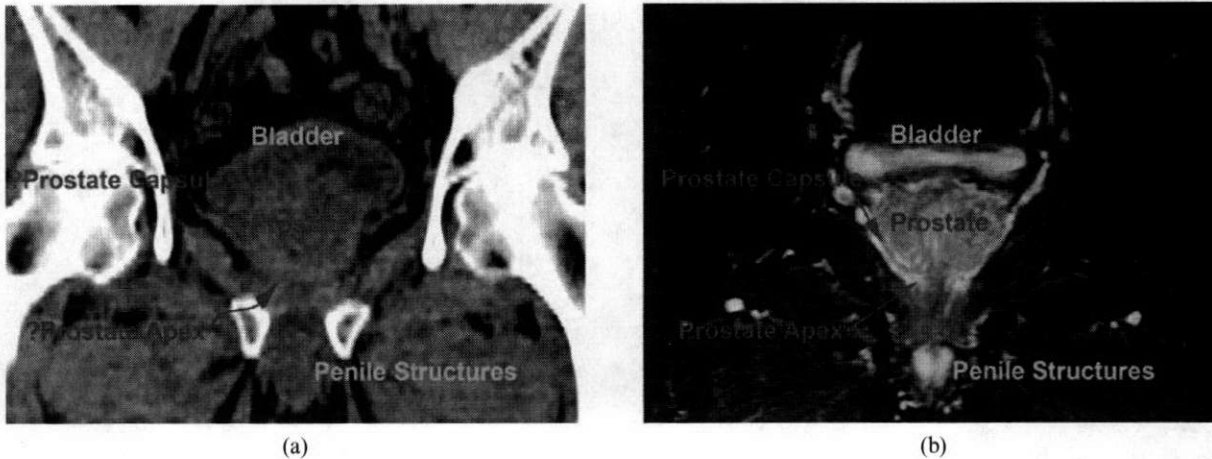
A comparison of coronal views of the pelvis for prostate radiotherapy with (a) CT reconstructed from 2.5 mm slices and (b) MR image obtained in-plane in the same patient. Definition of the prostate gland boundaries and the adjacent structures is better visualized on MRI than with CT.
